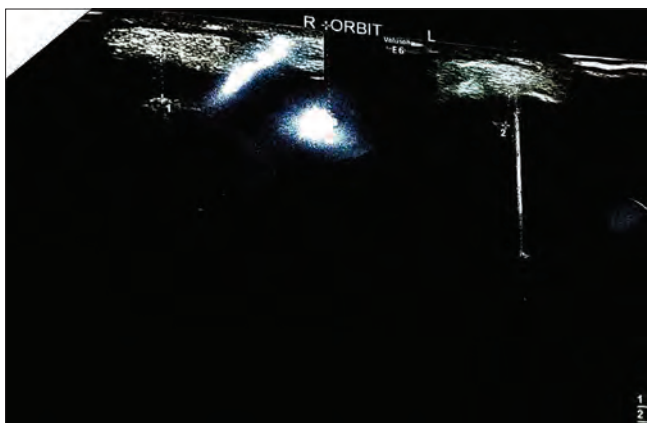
B mode ultrasound scan of the orbit in patient 2 showing the absence of both globes behind the lids
